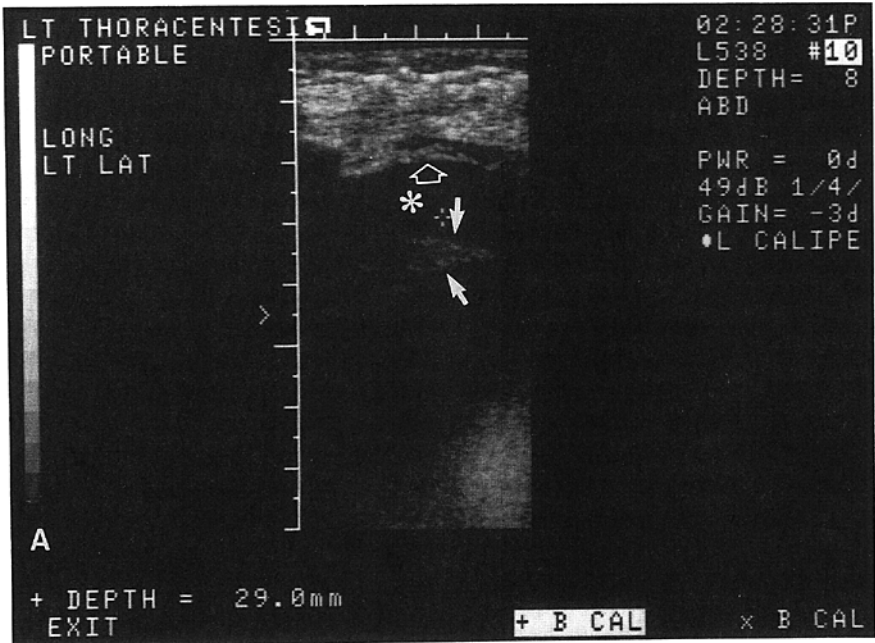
Simple pleural effusions with atelectatic lung parenchyma. (A) Real-time high-resolution ultrasound of the lower thorax and chest wall shows a simple pleural effusion (asterisk) with a region of atelectatic lung containing fluid within bronchi (arrows). Note an uncalcified pleural plaque (open arrow). (B) High-resolution ultrasound image in a separate patient shows a simple pleural effusion (asterisk) containing a region of consolidated lung. The echogenic artifacts are from air within the bronchi (arrows).
